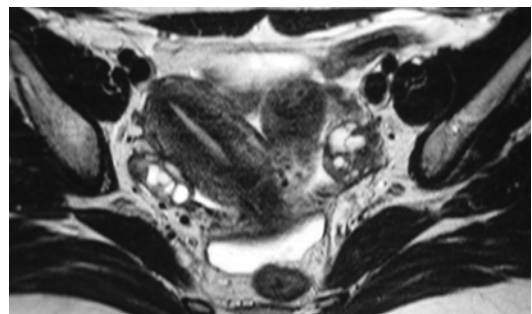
Right hemi-uterus with a left non-communicating rudimentary horn with cavity: magnetic resonance imaging (MRI) findings
